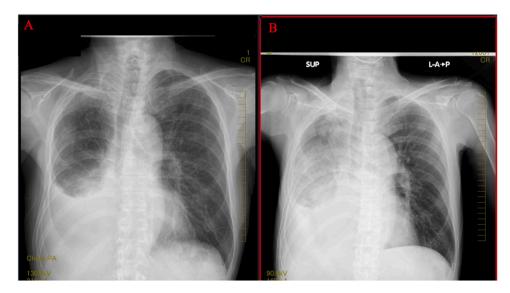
Chest radiography. (A) Chest radiography on admission shows pleural effusion in the right lower lung field; (B) the one performed on admission to the ICU, shows consolidation throughout the right lung field. Abbreviation: ICU, intensive care unit; CT, computed tomography.
